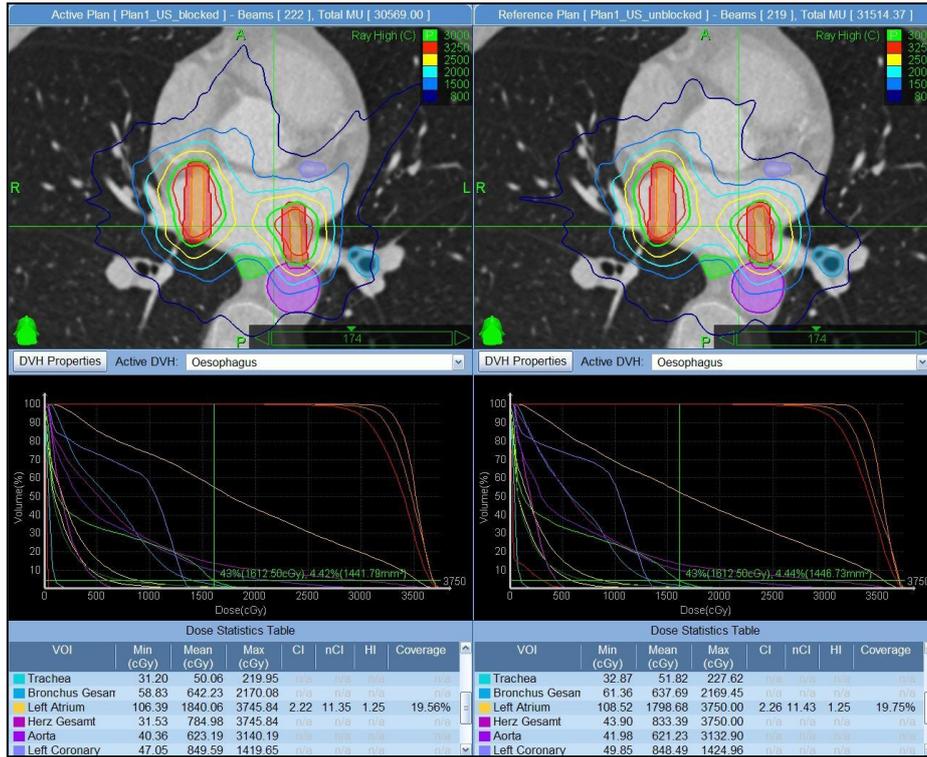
Robotic radiosurgery treatment plan with and without ultrasound tracking
